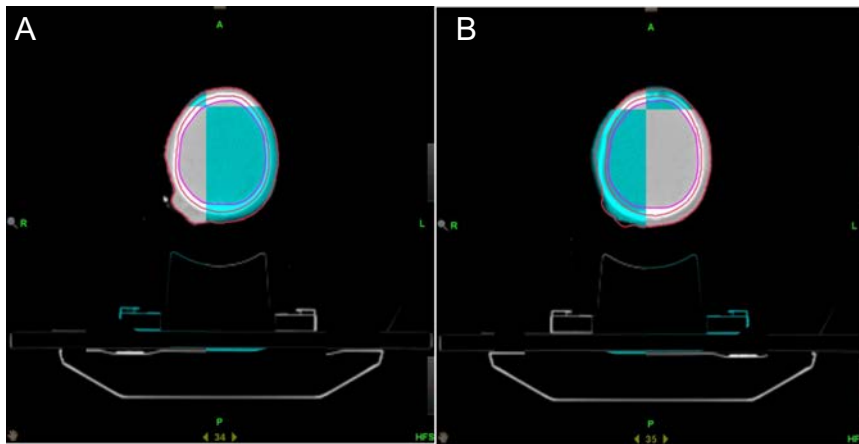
Megavoltage computed tomography transverse images of patient on day 1 (A) and day 8 (B), showing reduction in size of tumoral mass.
